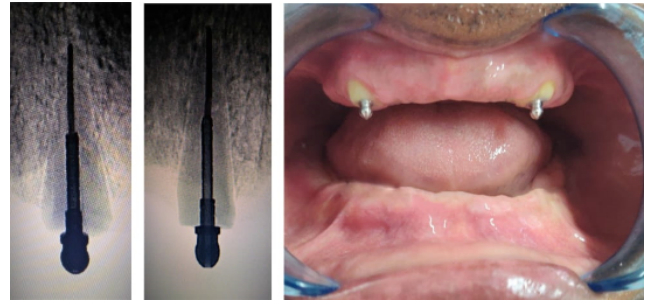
Luting and clinical and radiographic verification
